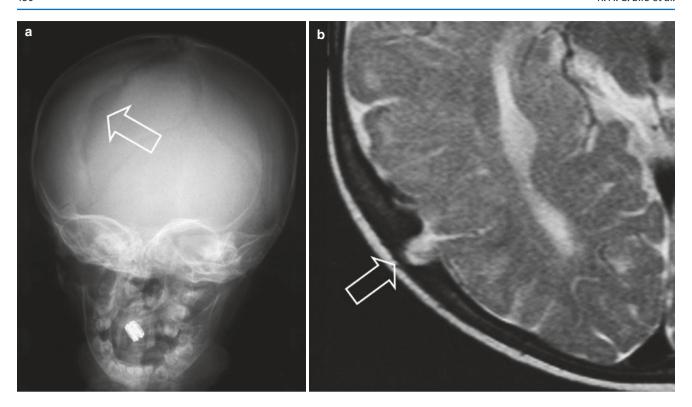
(a) Girl with a growing skull fracture. The skull view shows a diastatic fracture on the right dorsal parietal side. (b) Pre-operative MRI shows a dural defect and prolapsed meninges and brain tissue in the diastatic fracture (arrow)
